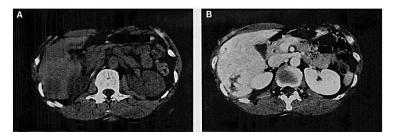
Images A and B show a hemangioma with the typical CT look before and shortly after the administration of contrast agent [31].
